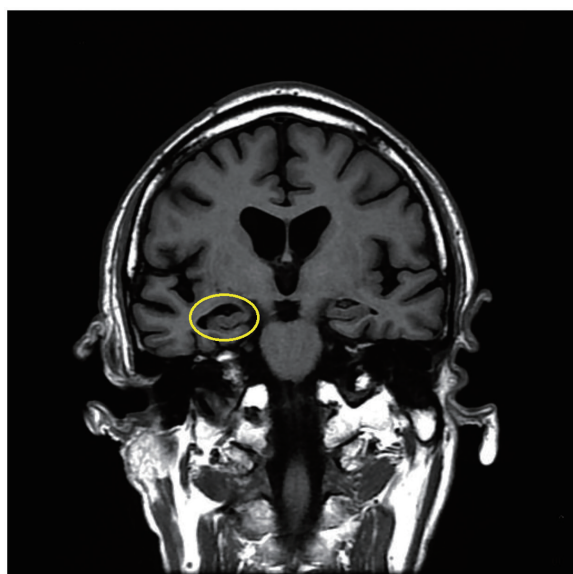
Brain magnetic resonance imaging findings (coronal section). There was a difference in hippocampal size on the left and right, but no abnormality was noted by the radiologist. We ultimately determined this finding to have little pathological significance.
